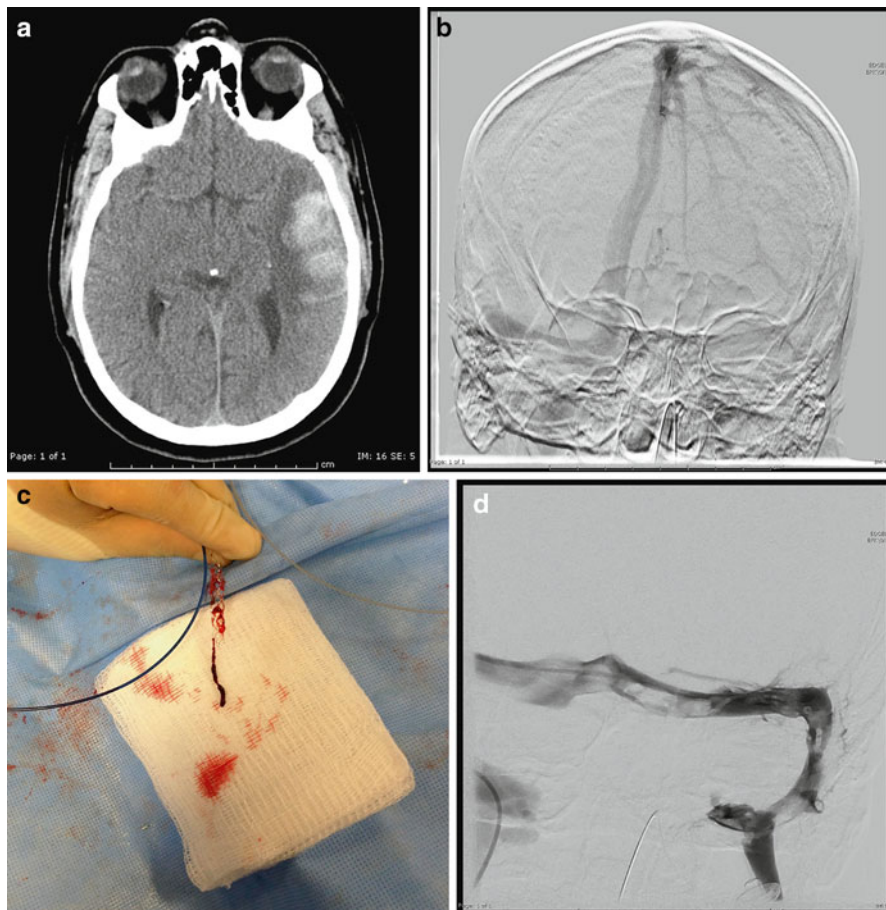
(a) Axial, non-contrast head CT shows a left temporal venous infarct with hemorrhagic transformation. (b) Anterior–posterior projection angiogram showing occlusion of the left transverse sinus (TS) and sigmoid sinus (SS). (c) Extensive clot extracted with the aid of the Solitaire stent retriever. (d) High-magnification retrograde venogram showing restoration of venous drainage in the left TS and SS
